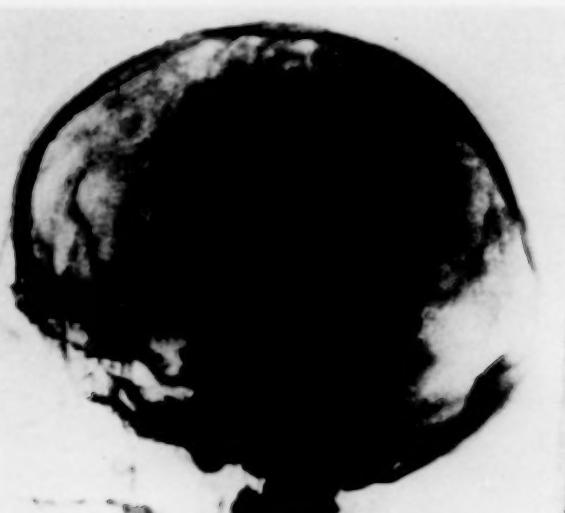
CASE I. Roentgenogram of skull.
